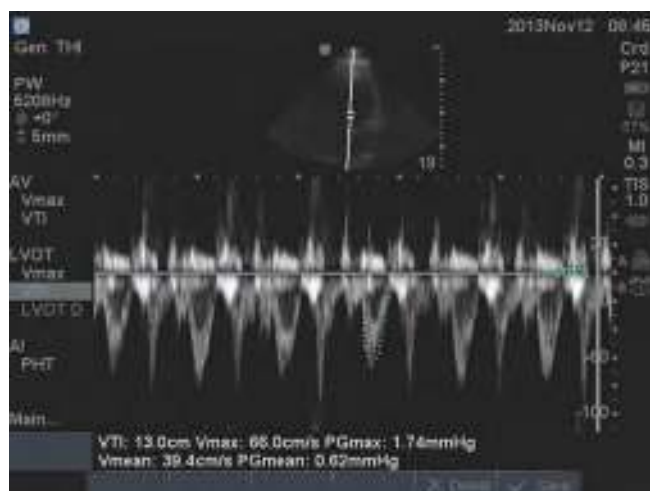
Measurement of LVOT Δ VTI and ΔV_{\max} using an apical five-chamber window. See text for details.
